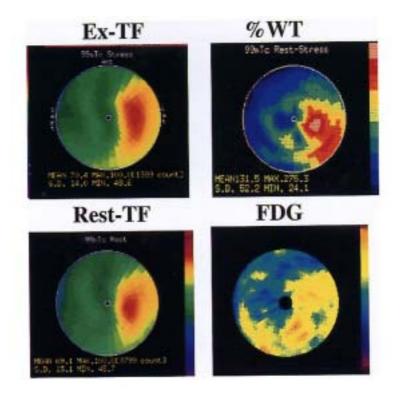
A 72-year-old female patient with previous anterior wall myocardial infarction (see text). *Left*, polar map of % uptake of Ex/rest TF. *Right upper*, polar map of % WT. *Right lower*, polar map of % uptake of FDG.
